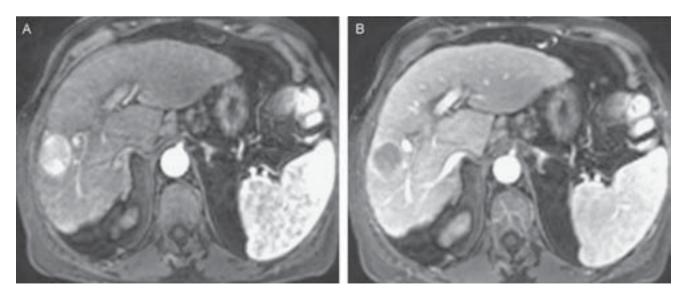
A 30-mm HCC in the right hepatic lobe with a characteristic vascular pattern on a dynamic MRI study. A) In the arterial phase, the lesion is intensely enhanced in relation to the neighboring liver. B) In the portal phase, the nodule washes its contrast more quickly than does the surrounding liver.
